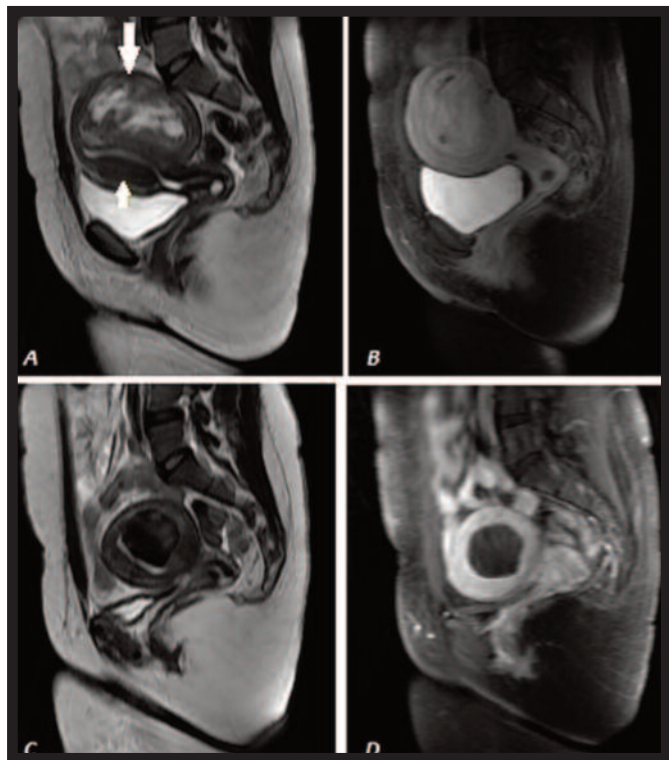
(A) Intramural myomas 4x2 cm in size (big arrow) in the anterior uterus and 8 cm in diameter (small arrow) in the posterior uterus are observed on preoperative sagittal T2W MRI investigation. (B) The myoma is seen to enhance more intensively than the myometrium on preoperative sagittal T1W contrast MRI investigation. (C) The diameter of the posterior myoma has regressed to 3.5 cm and has a homogenous hypointense appearance at the postoperative third-month sagittal T2W MRI investigation. The myoma and myometrium borders are sharpened. The myoma observed anteriorly at the previous investigation has disappeared completely. (D) The myoma has become hypointense due to devascularization at the postoperative third-month sagittal T1W contrast MRI investigation.
